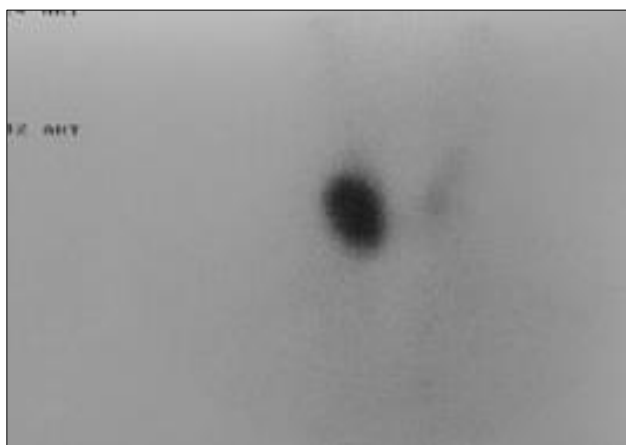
Thyroid scintigraphy showing hyperfunctioning nodule on the right side.
